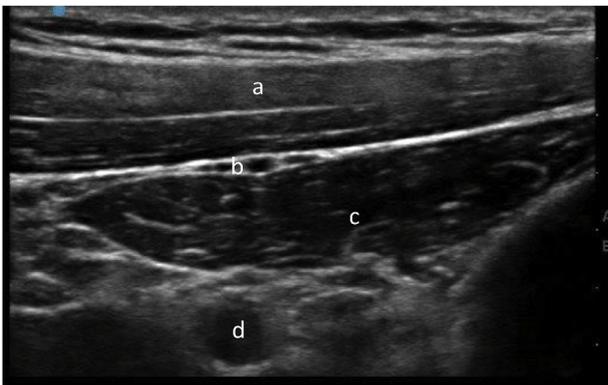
Ultrasound-guided PECS I block (depth 3.3 cm). (a) Pectoralis major; (b) lateral pectoral thoracoacromial artery; (c) pectoralis minor; (d) axillary artery.
